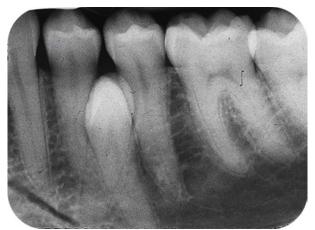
Periapical radiograph of talon cusp anatomy on a peridens impacted between mandibular left premolar teeth #20 and #21
